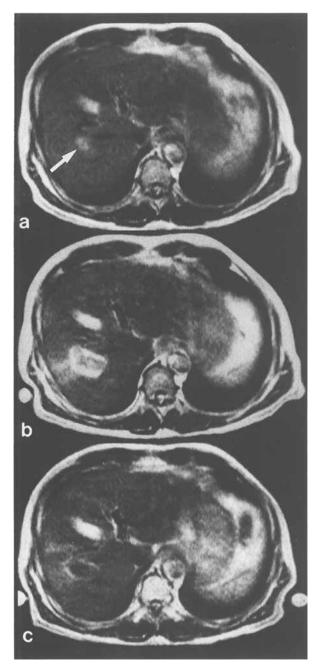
(Patient 14): MRI (T2-weighted images). (a) Before treatment. The tumor site (white arrow) was demonstrated as a high-intensity area. (b) One day after treatment. The tumor site became a low-intensity area, and a high-intensity ring appeared. (c) Two weeks after treatment. The change to low intensity was more marked, and the high-intensity ring was less marked.
